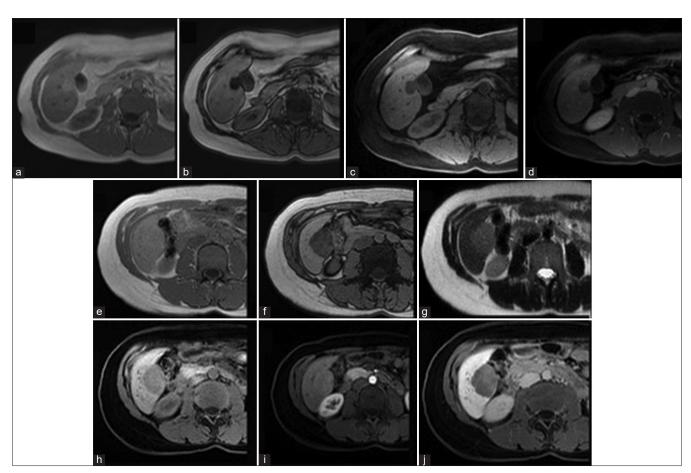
(a-d) A 42-year-old female with hepatic angiomyolipoma and (e-j) a 45-year-old female with hepatic adenoma, both incidental findings. (a and b) T1 chemical shift abdominal MRI showed a hyperintense mass during (a) in-phase with signal loss during (b) opposed-phase. (c and d) T1-weighted fat saturation image showing hypointense mass (c) with enhancement after contrast administration (d). (e and f) T1 chemical shift abdominal MRI showed hyperintense mass during in-phase (e) with signal loss during (f) opposed-phase, and with hyperintensity in T2-weighted image (g). T1-weighted sequence (h) showing mild hypointense mass with poor enhancement in late arterial phase (i), followed by washout during delayed phase (j).
